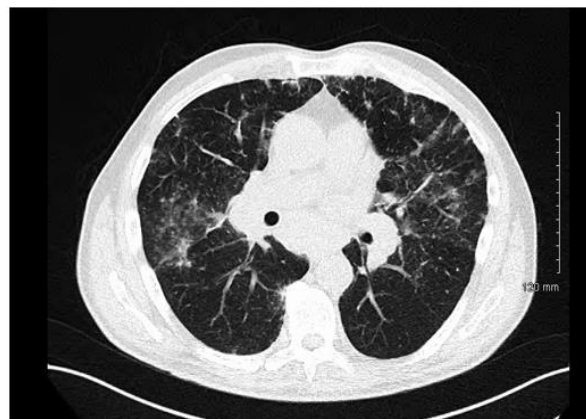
CT Thorax - suggestive of sarcoidosis.
